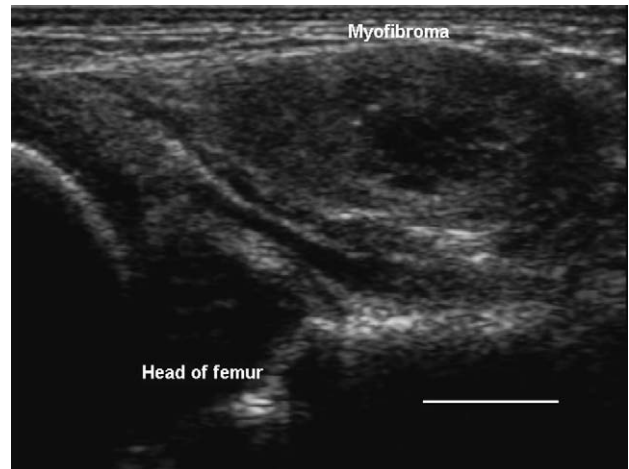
Ultrasound image of the left hip region after birth: nodule 2.0 × 1.0 cm in diameter, central part partially anechoic, thick surrounding tissue wall, embedded in muscle tissue, no bone involvement of the hip, but infiltration of adjacent ligaments and capsule structures. Bar, 1 cm.
